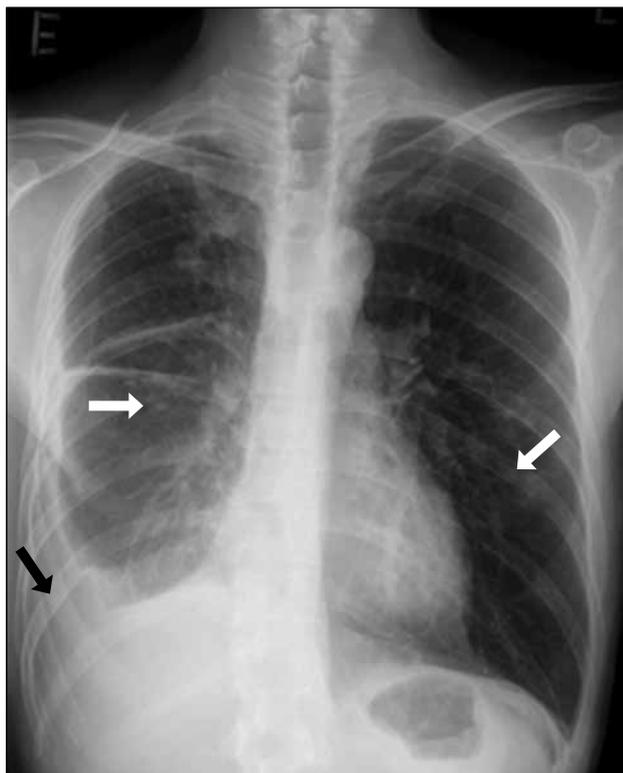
Chest X-ray shows right pleural effusion (black arrow) and several subcentimetre lung nodules in both lungs (white arrows).
